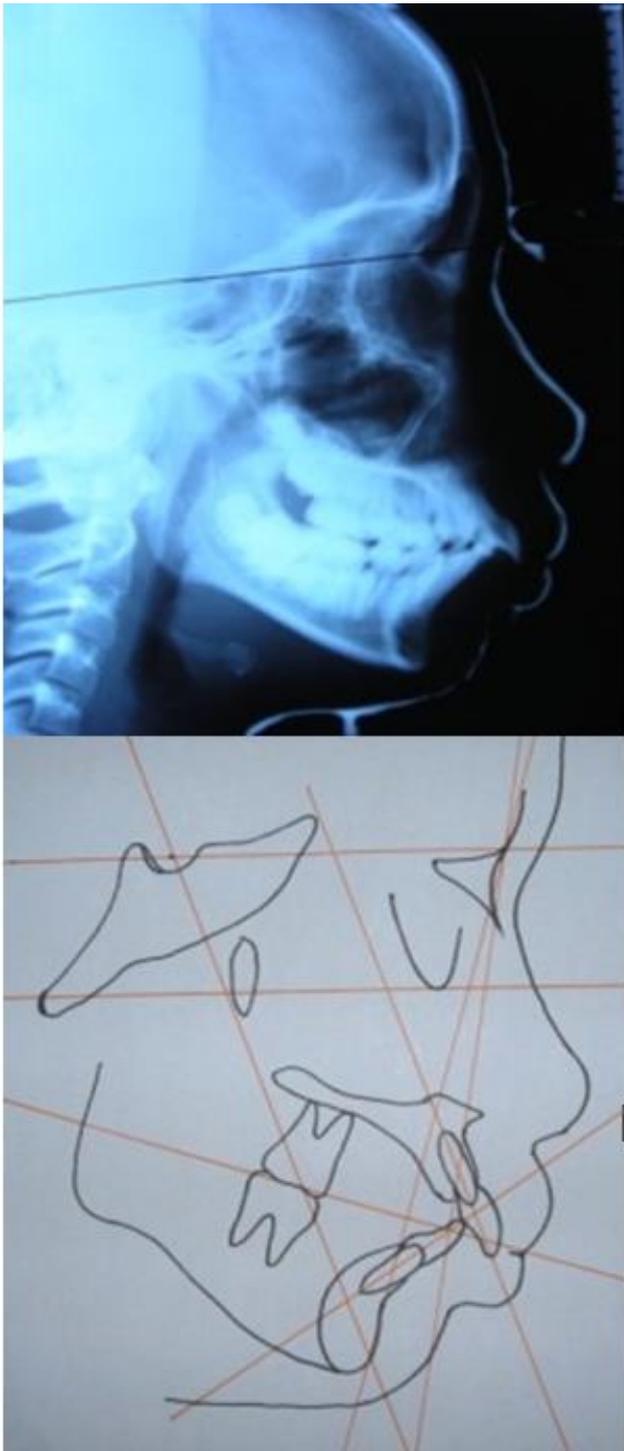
Cephalometric radiographs.
